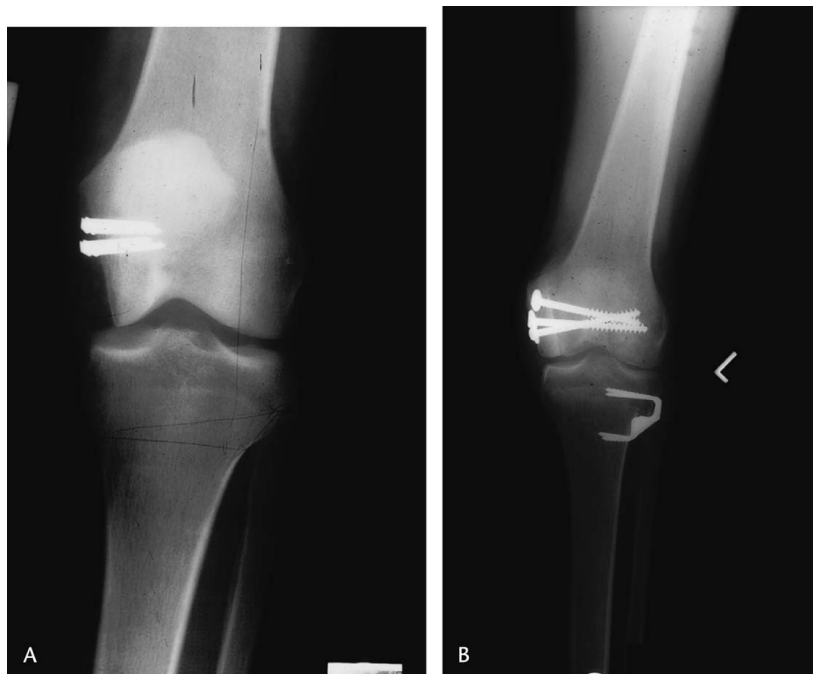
(A) An AP xray of left knee of 35-year-old man with traumatic loss of medial femoral condyle is shown. (B) An AP xray of his left knee 8 years after reconstruction with fresh medial femoral condyle allograft and valgus closing-wedge proximal tibial osteotomy is shown.
